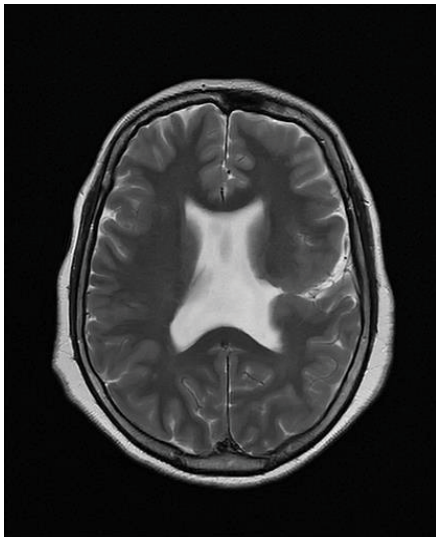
Magnetic resonance, T2-weighted images, axial section showing the left frontal sulcus widened and communicated with the left ventricle, and widening of bilateral ventricles.
